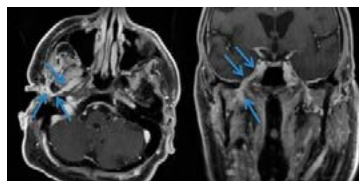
Example of perineural spread along the right AT nerve from a scalp squamous cell carcinoma on MRI. There is abnormal enhancement (blue arrows) within the infratemporal fossa extending along the skull base and through foramen ovale.
